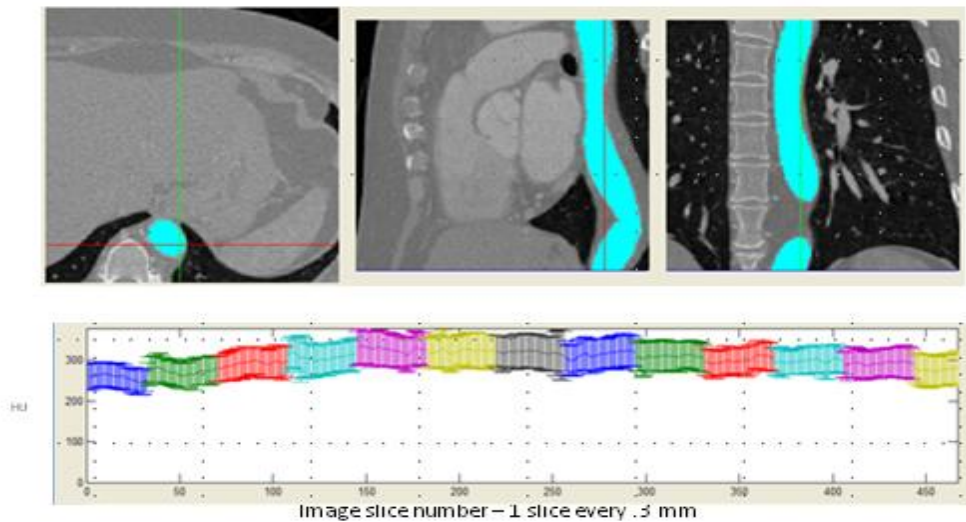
Example CTA data set (top – the shaded structure is the descending aorta) and contrast enhancement values derived from the aorta (bottom). The colored blocks indicate that the multiple slices within that block were acquired at one time instance.¹
